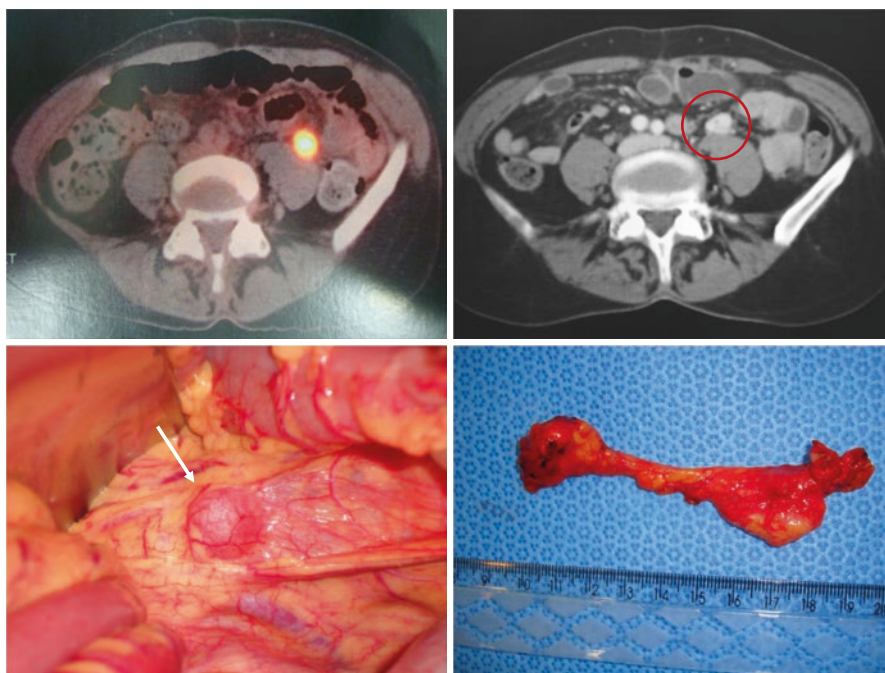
A 63-year-old female patient previously treated for lung cancer. In follow-up exams, a solid nodule was noted in the anterior portion of the left psoas muscle with increased metabolism on PET-CT. The patient underwent an image-guided biopsy that revealed the diagnosis of high-grade leiomyosarcoma. During the operation, it was possible to conclude that it was a primary leiomyosarcoma of the left gonadal vein
